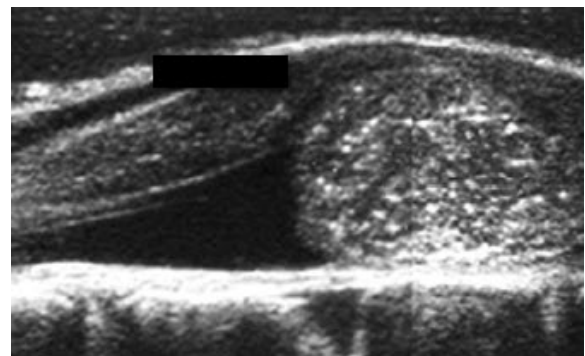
The shape of the linear probe was hockey-stick like (bottom left) and fitted perfectly into small openings like a hemilaminectomy (top left). This way, the minimal invasive opening did not have to be enlarged just for desired imaging. These linear ultrasound probes work in a high-frequency range (7-14 MHz) and deliver high resolution in near field imaging (image below).
